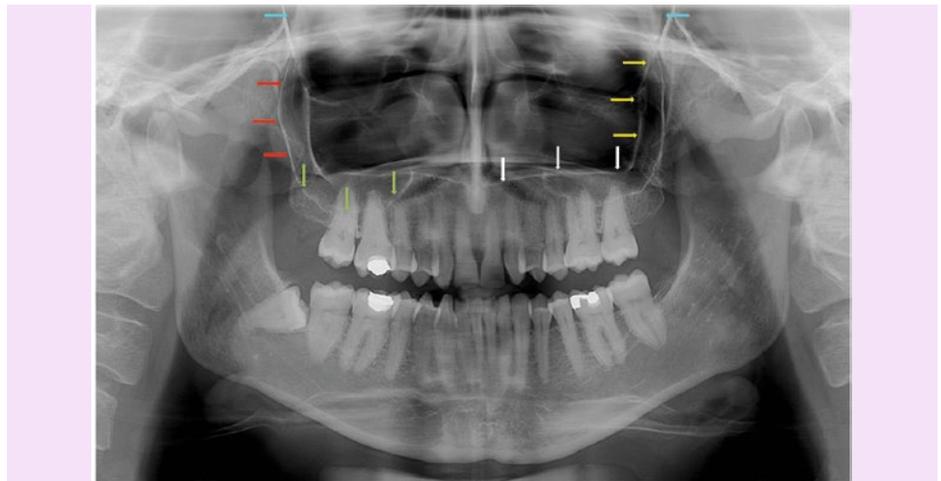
Dental panoramic radiograph demonstrating aerated maxillary sinuses with intact cortical borders; antral floor (green arrows), posterior wall (red arrows), zygomatic buttress (yellow arrows), hard palate (white arrows) and pterygomaxillary fissure (blue arrows). The integrity of these cortical boundaries should be assessed as part of the methodical evaluation of all panoramic radiographs
